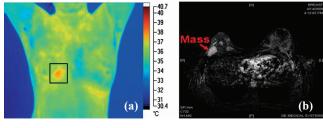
(a). Breast thermal scan image of *Case 2* showing the abnormality. (b) MRI scan image of *Case 2* showing the same abnormality.
